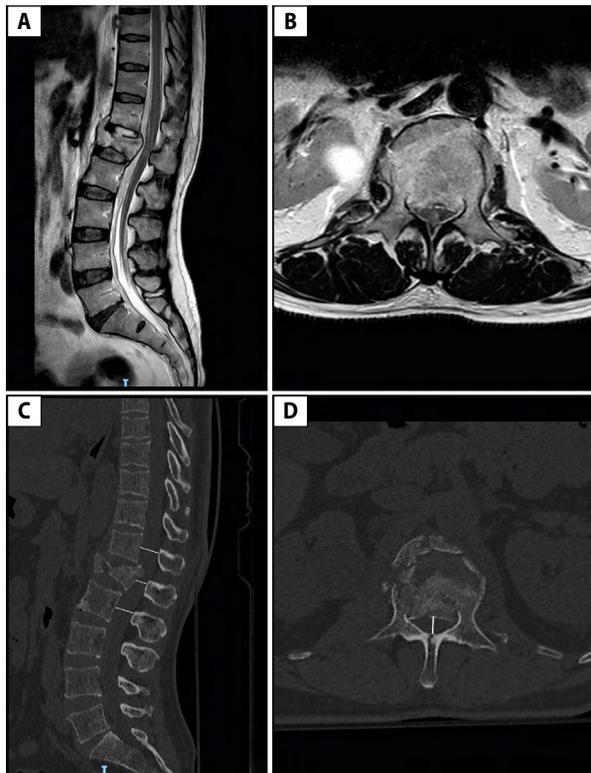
Pre-operative radiological evaluation. All included patients received pre-operative magnetic resonance (MRI, panels A, B) and computed tomography imaging (CT, panels C and D). Extent of maximal spinal canal compression has been systematically evaluated on CT images. Maximal reduction in canal diameter was defined as distance from posterior aspect of bone fragment and anterior wall of posterior arch on a midsagittal location, as shown in panel D. This measure was compared to mean canal diameter measured at upper and lower levels (as depicted in panel C). All measures were performed on axial CT slices. See text for further details
